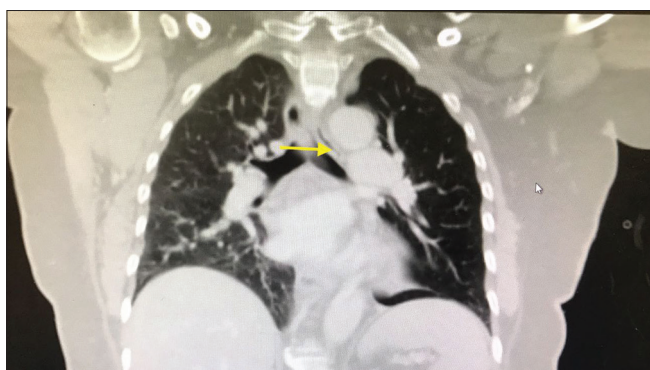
Spiral computed tomography showed endobronchial soft-tissue lesion within the left main bronchus measured 1 cm with subsequent total collapse of the left lower lobe and hyperinflation of the left upper lobe. No lymph node involved
